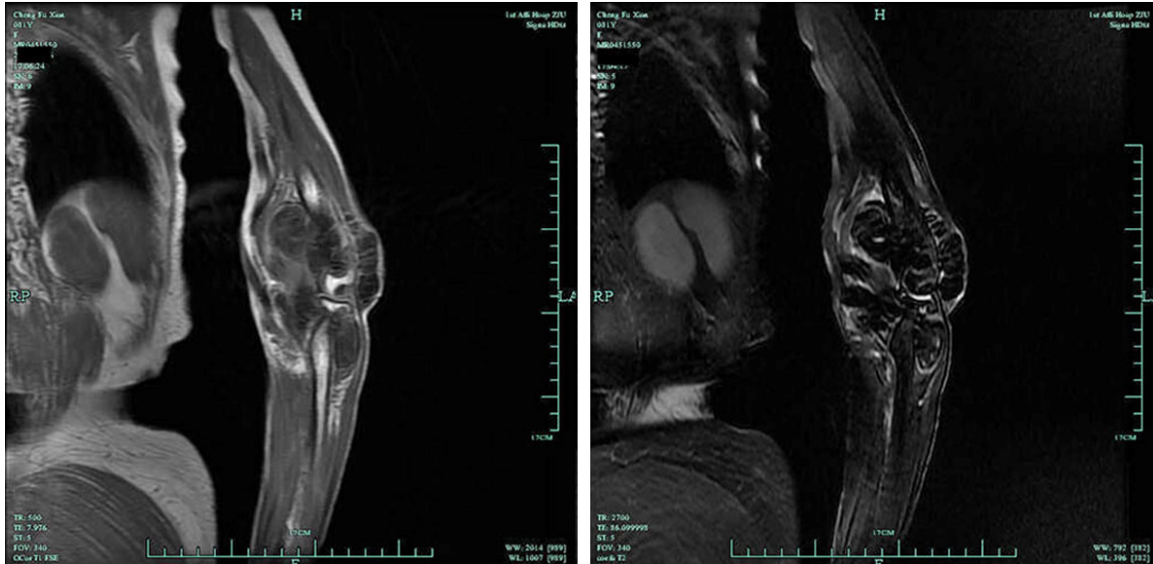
MRI of pre-operation showing T1-weighted images. Multiple masses located in internal and external joint showed mildly low signal intensity to muscle; T2-weighted images. they showed hyper- or isointense to muscle signal intensity.
